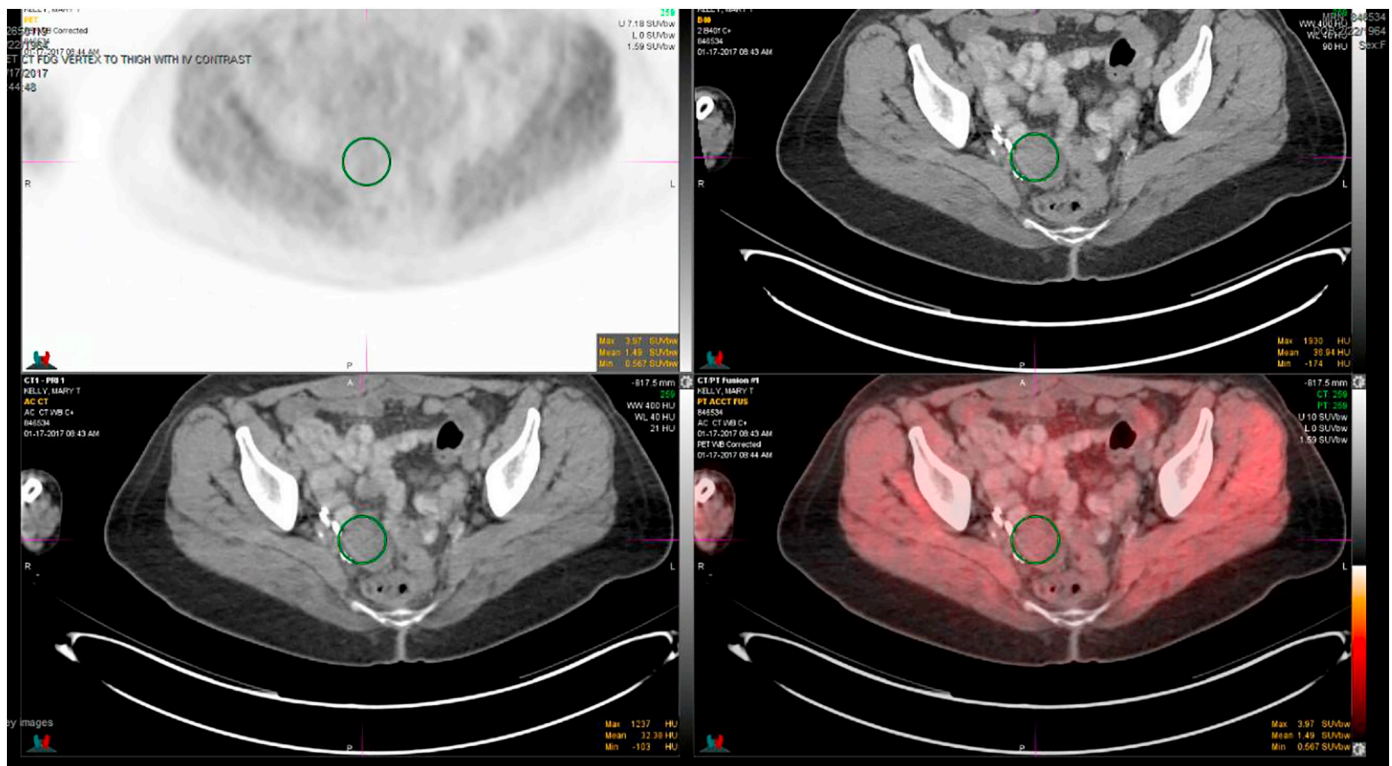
Fused PET-CT images of pelvic nodule near vaginal cuff with increased FDG-uptake on post-chemotherapy imaging.
